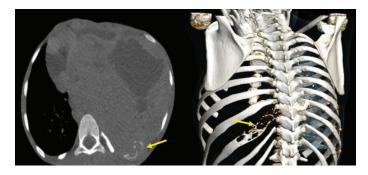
Contrast-enhanced axial (A) in the bone window and posterior 3D VRT view (B) images of CT chest showing partial lysis of the posterior costal arch of the 9th left rib.
